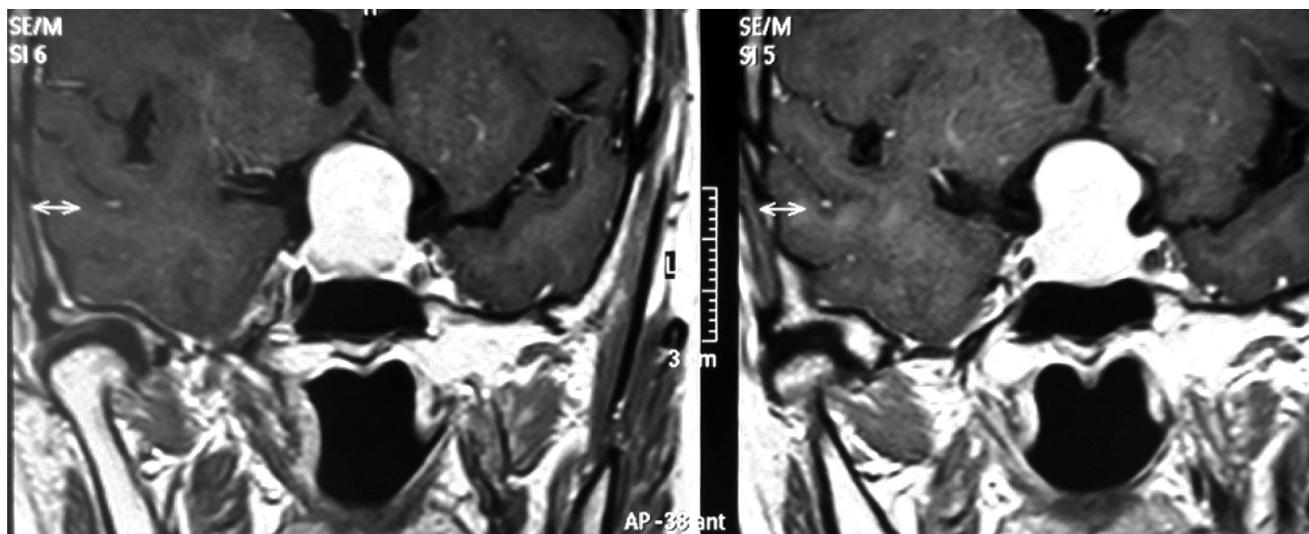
Preoperative contrast enhanced MRI, coronal image with preoperative tumor volume of 7.95 ml with Knosp II (on the left) and Hardys B class
